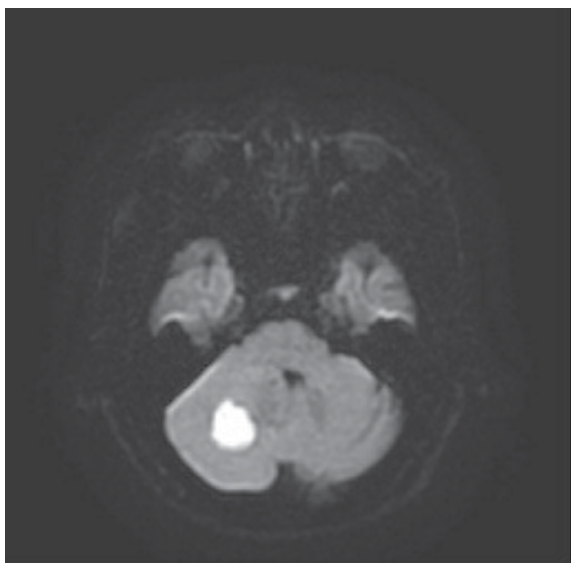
Pre-operative brain MRI DWI showed contrast enhanced lesion over the superior vermis and right cerebellum.
